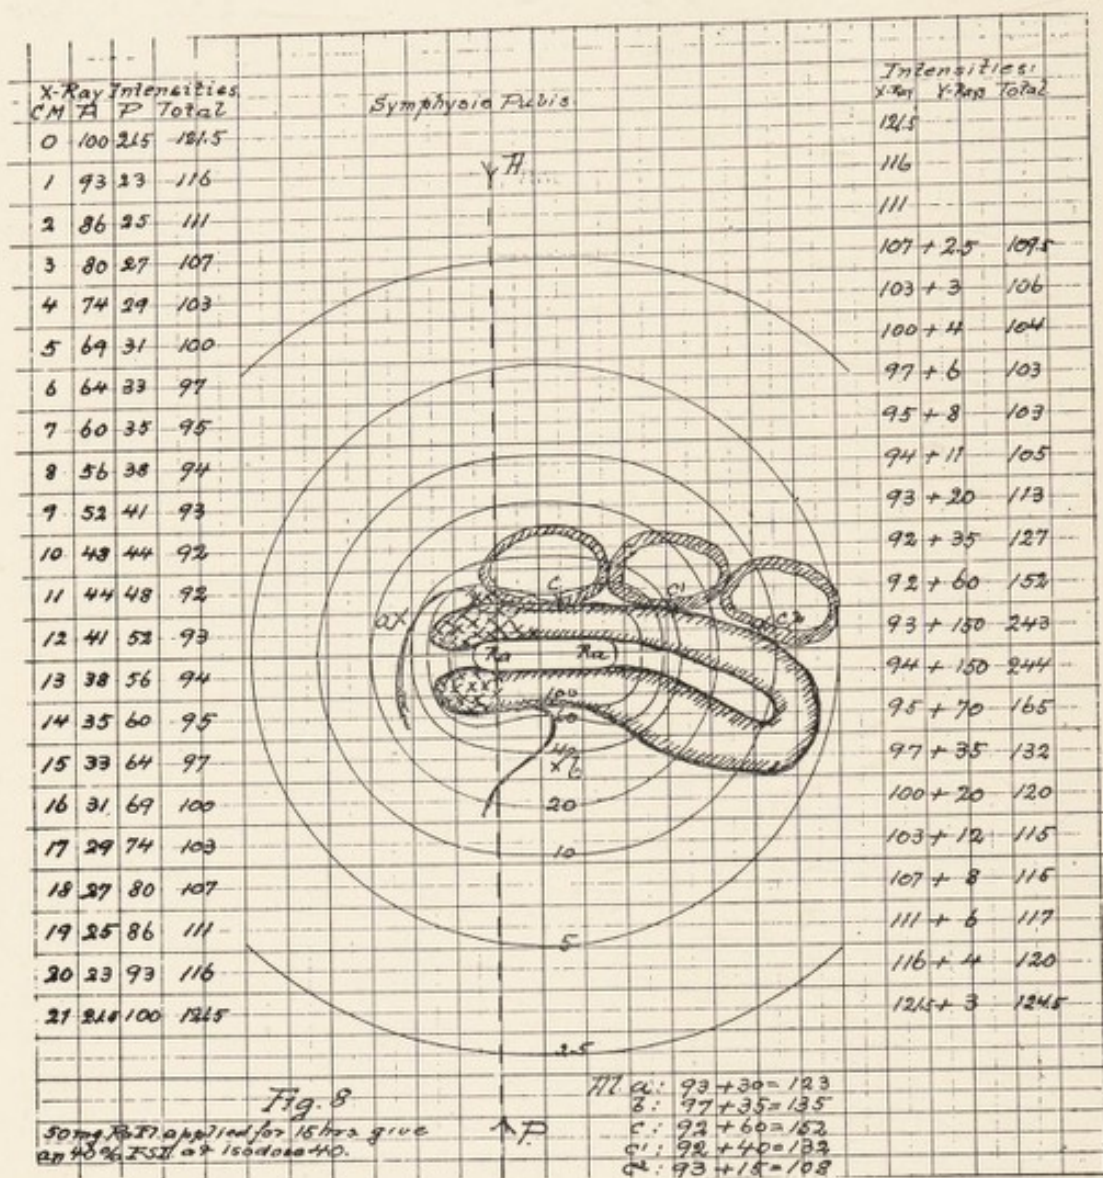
THE CALCULATION OF THE COMBINED RADIUM AND X-RAY DOSE IN A UTERINE CARCINOMA. The uterus is in retroversion. Points  $c$ ,  $c^1$  and  $c^2$  indicate the position of the small bowel,  $a$  the posterior bladder mucosa, and  $b$  the anterior rectal wall.
